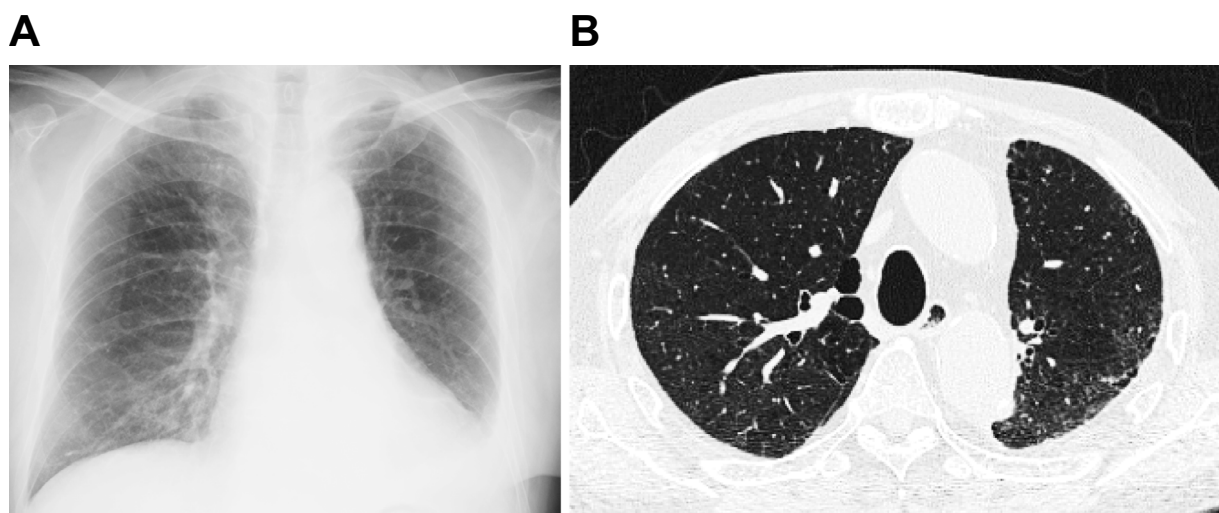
Chest X-ray film (A) and high-resolution computed tomography (B) on two weeks after discontinuation of apixaban and administration of prednisolone therapy revealed remarkable improvement.
